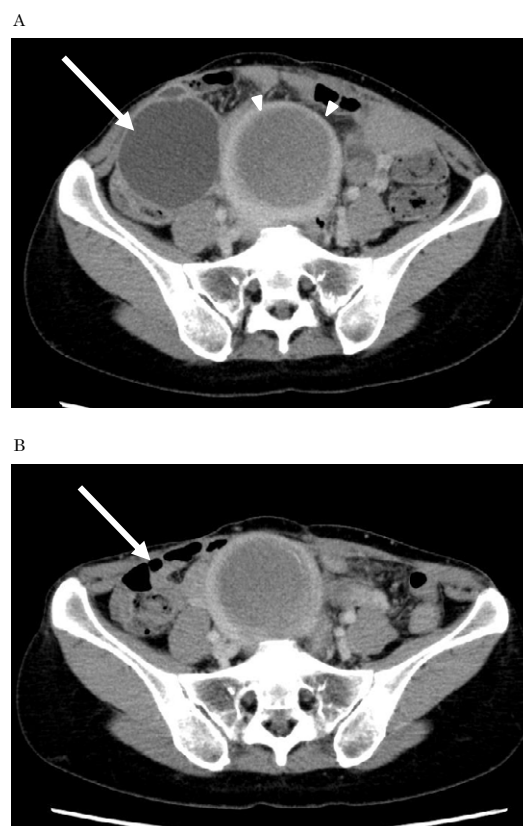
Computed tomography scan of the pelvis. A: Pre-drainage examination shows the right adnexal mass with wall thickening (arrow) and an infarcted myoma (arrow heads). B: Post-drainage examination shows resolution of the previously seen right adnexal mass (arrow).
